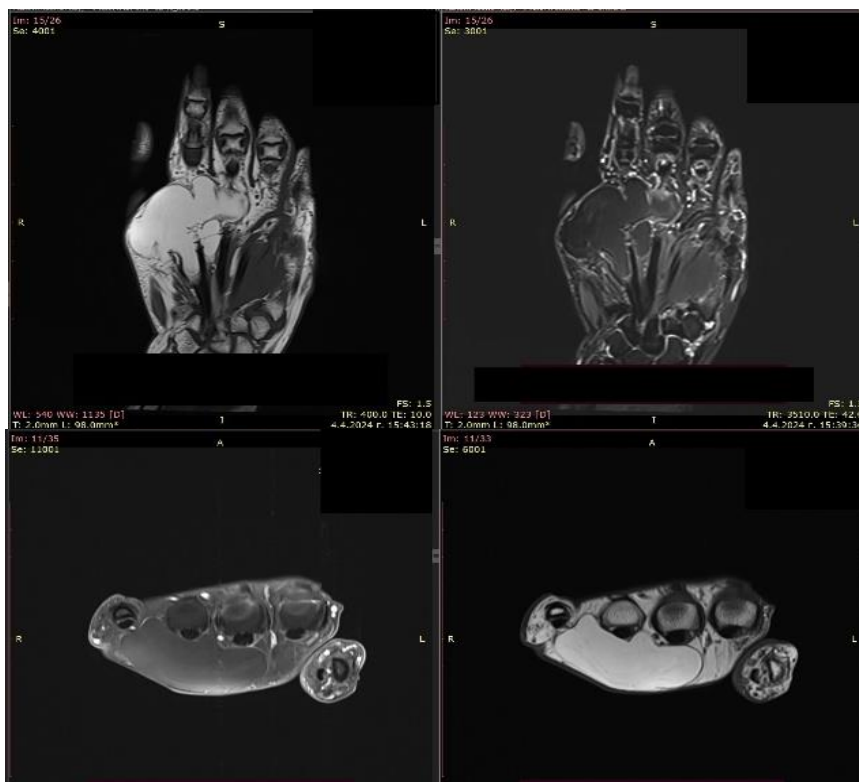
Axial and coronal T1-weighted MRI images with fat signal suppression of the hand, demonstrating suppression of signal from the lipoma.
